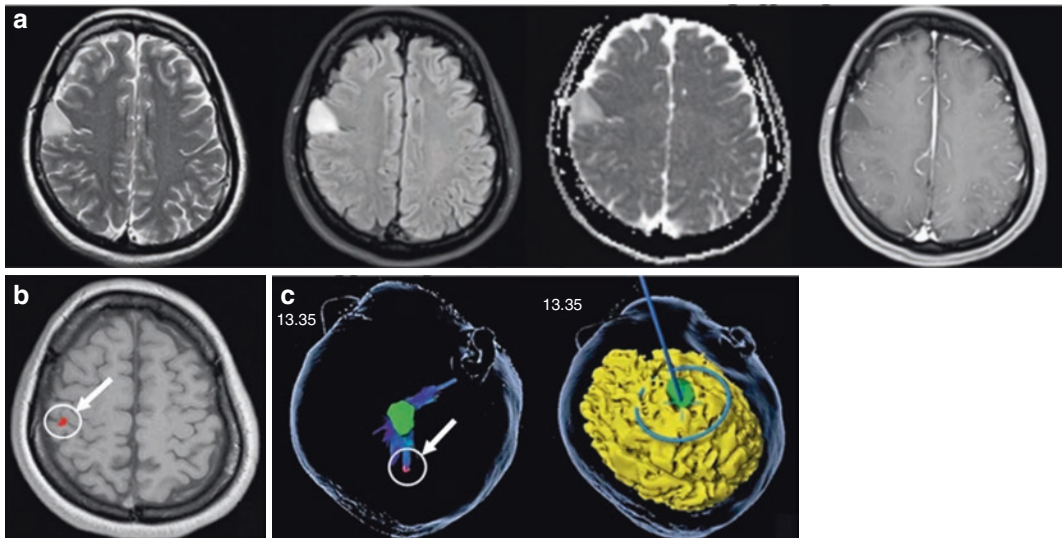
Right frontal lobe oligodendroglioma, WHO grade II. A 27-year-old female patient, in whom a space-occupying lesion was discovered in the right frontal lobe 3 months ago. Patient's preoperative MRI, which revealed that the lesion was adjacent to the motor areas (a).
